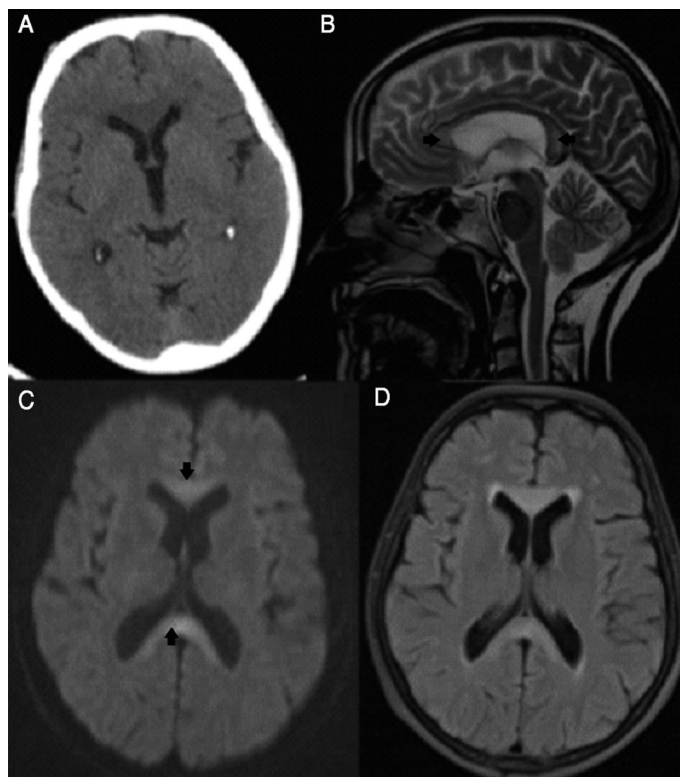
A) Axial computed tomographic image (soft-tissue algorithm) showing a hypoattenuating lesion involving the genu of the corpus callosum. B-D) Brain magnetic resonance images: B) sagittal, T2-TSE; C) axial, diffusion-weighted imaging (DWI); D) axial, T2-FLAIR. Hyperintense lesions involving the entire corpus callosum were seen on T2-TSE and T2-FLAIR sequences. The same lesions were also hyperintense on DWI, with a low apparent diffusion coefficient reflecting restricted diffusion.
